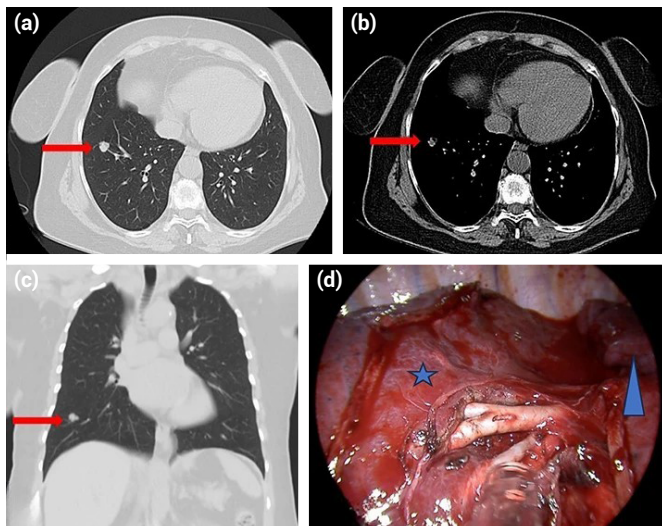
Thoracic computed tomography; right lung lower lobe fissure neighbor anteriorly lobulated parenchymal nodule with 12.5 mm diameter (arrow) (a) In sections in the parenchymal window (b) In sections in the mediastinal window (c) In sections in the coronary section parenchymal window (d) Surgical image, lower lobe (star) upper lobe (triangle).
